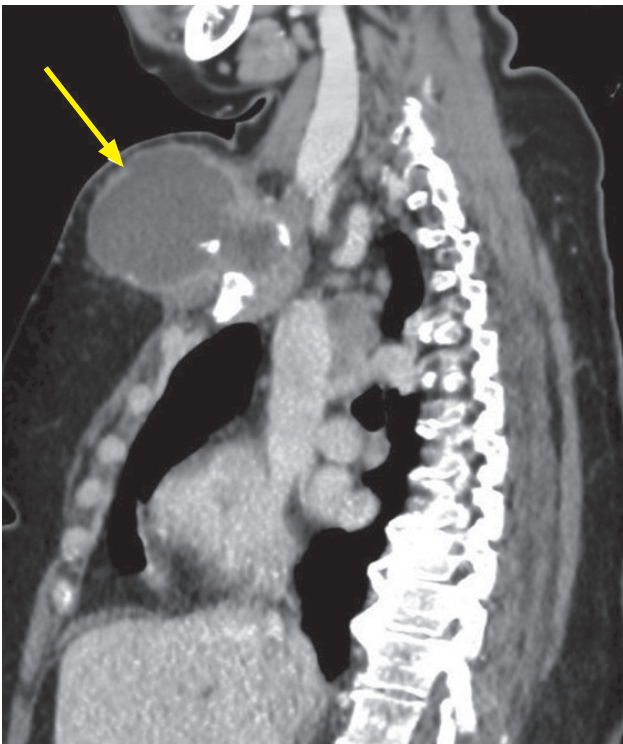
Computed tomography (CT) thorax (sagittal view) post-contrast images show the lesion with central areas of necrosis and a thick peripherally enhancing capsule.
